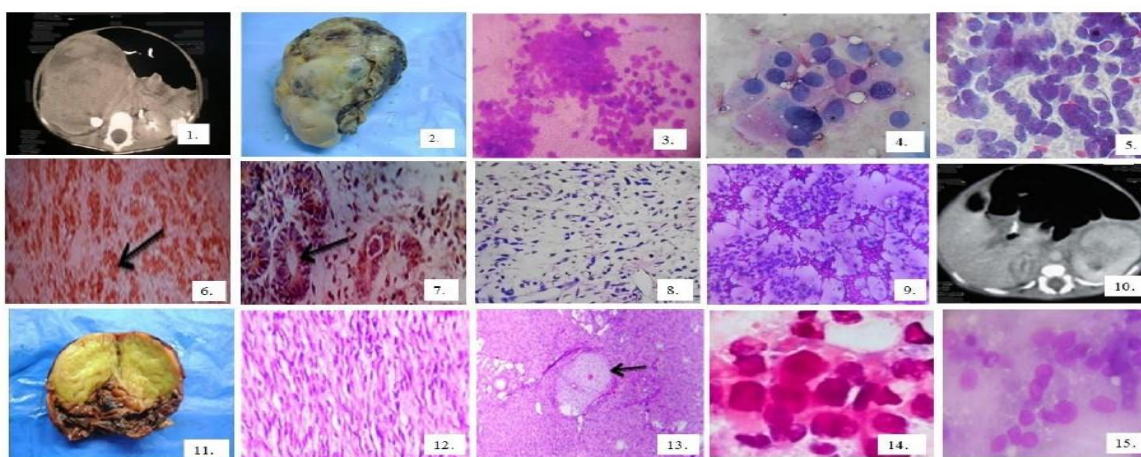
CT abdomen shows heterogenous soft tissue mass on right sided kidney (Wilms tumor).
